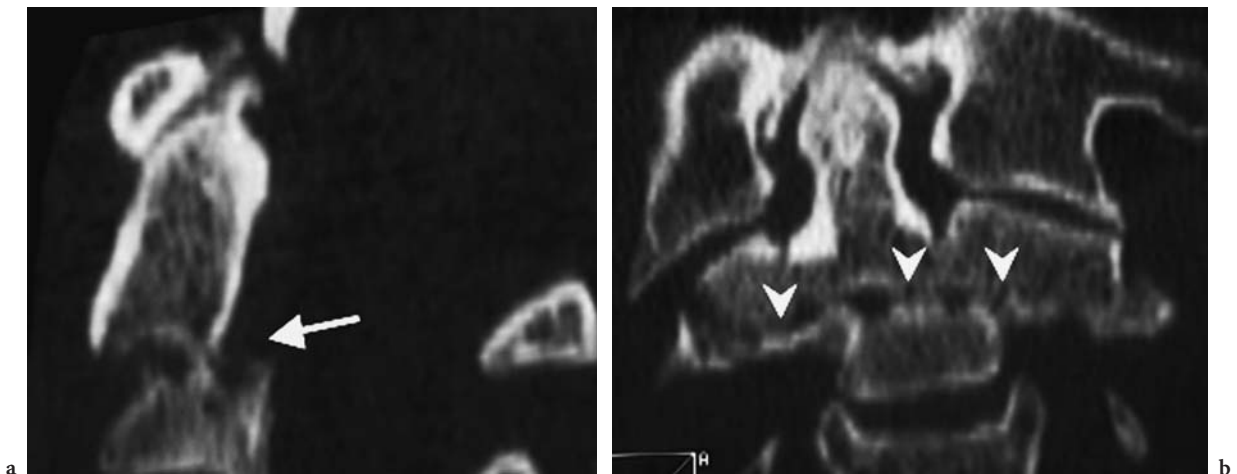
Odontoid fracture: type III. a Sagittal CT reformation. b Coronal CT reformation. Fracture extending into the body of C2 (arrow and arrowheads)
